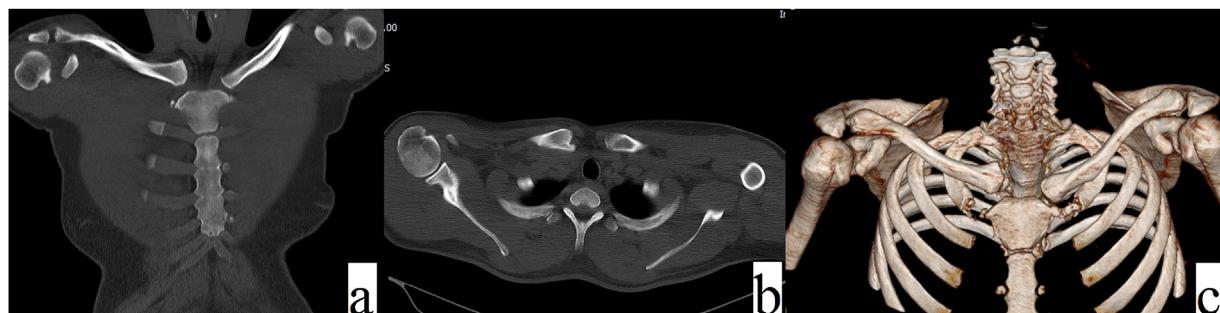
Chest CT scan of our patient (coronal (a), axial (b) and 3 dimensional views (c)) demonstrates superior dislocation of the right sternoclavicular joint.
